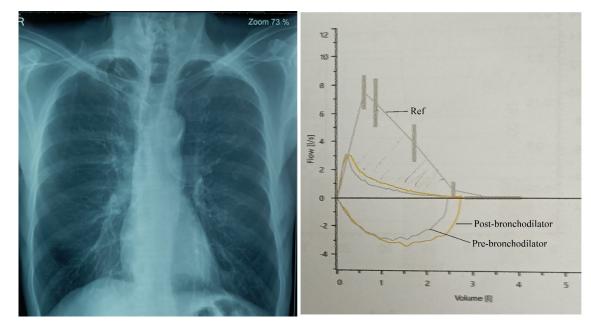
Chest X-ray showing the COPD like changes and Spirometry flow-volume loop showing the patients pre and post-bronchodilator graph in relation to the reference one.
